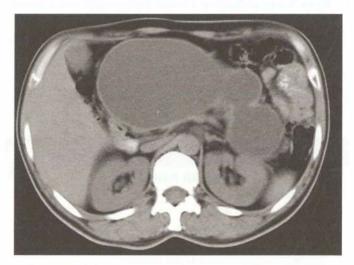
CT scan showing large pseudocyst with multiple pockets. Cystojejunostomy is the ideal treatment
